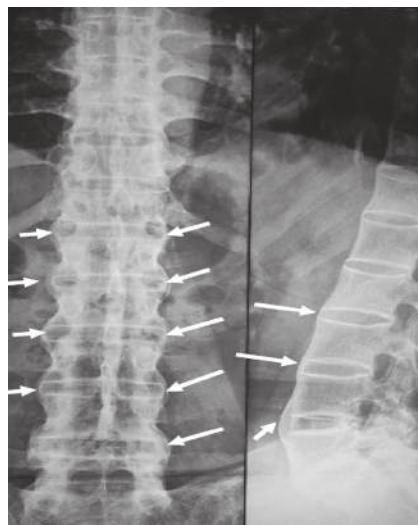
Classical 'bamboo spine'. Plain radiograph of spine in a patient with ankylosing spondylitis (now called axial spondyloarthritis) of long duration. Note the fine calcified lateral, anterior and posterior spinal ligaments with classical syndesmophytes (white arrows)
